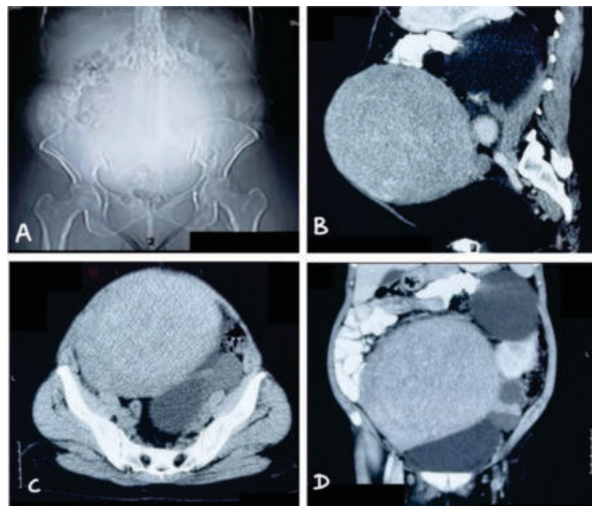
CT reveals extensive abdominal enlargement in the scout view
